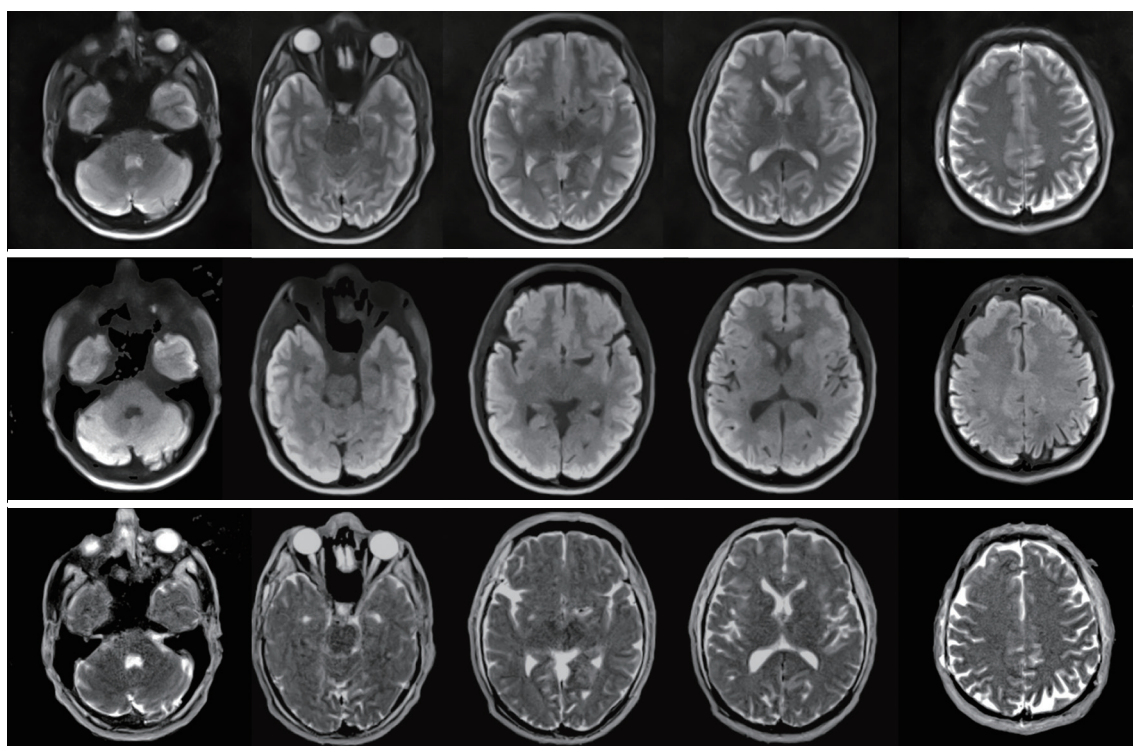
(Top row) non-diffusion-weighted (non-DW) images ($b = 0$), (middle) mean DW images ($b = 1,000 \text{ s/mm}^2$, 6 gradient directions) and (bottom) apparent diffusion coefficient (ADC) maps of the brain of a healthy volunteer as obtained by DW single-shot stimulated echo acquisition mode (STEAM) MRI. The 5 slices (left to right) are selected from a series of 51 directly neighboring cross-sections at 3-mm thickness. The total measuring time was 2 min 30 s. For other details see *Table 1*.
